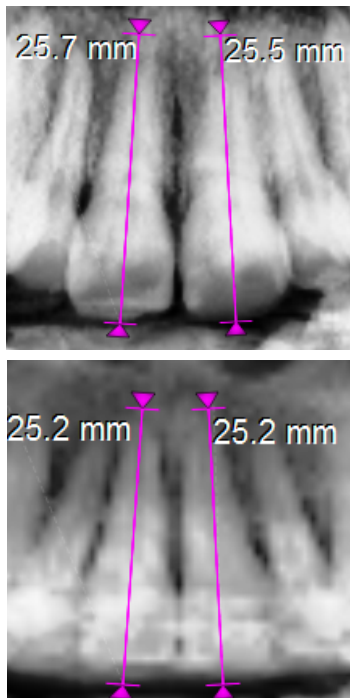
Pre Treatment and Post Treatment CBCT (Conventional Brackets)
